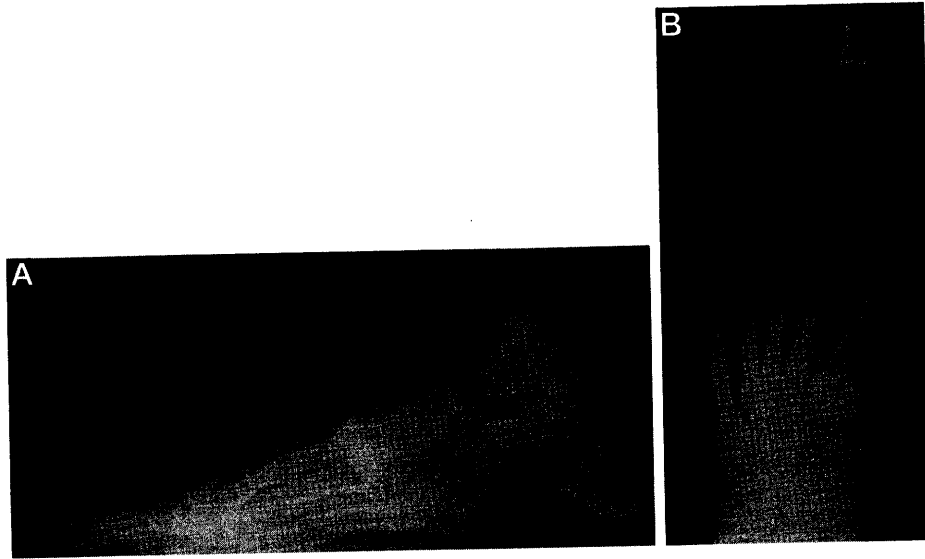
A, Lateral radiograph of left foot 33 weeks postoperatively. The first metatarsocuneiform joint appears fused, with graft site showing steady incorporation. B, Anterior-posterior radiograph of left foot 33 weeks postoperatively. Additional correction of intermetatarsal angle could have been achieved, but the main goal of joint fusion appears to be radiographically successful. While a step-off is evident at medial cuneiform, this has not affected the patient clinically.
